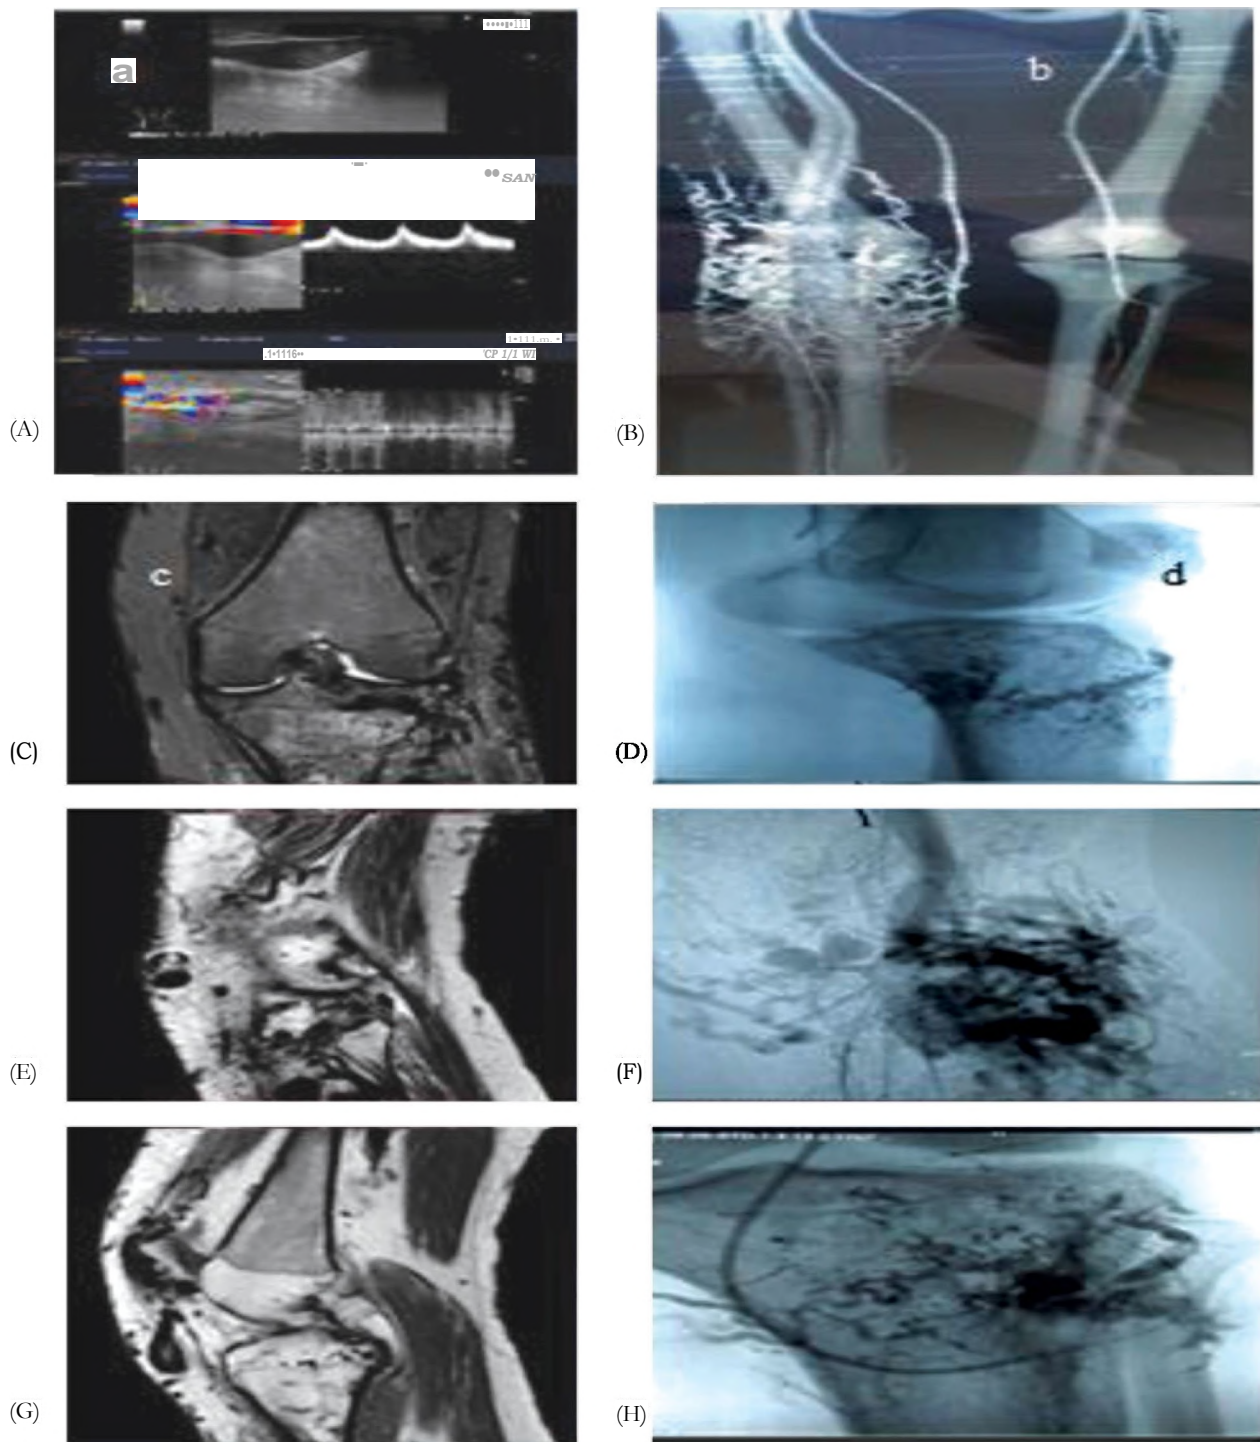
22 year old male patient complaining of multiple right knee joint pain, bluish swellings with eczema, ulcerations and redness of the right leg. A: Grey scale and color Doppler study of the right knee joint showed multiple dilated vascular channels with high flow detected on pulsed wave study. B: Reconstructed CT angiography image showing multiple dilated vascular channels around the knee joint. C: MR images STIR coronal and sagittal T1 and T2 showing multiple serpiginous signal void structures in all varicose veins and Diagnosis: High flow AVM with 2pulse sequences. D: Conventional angiography images lateral and oblique views showing part of the AVM embolization, Angiography and endo-vascular embolization was done on several sessions for the patient.
